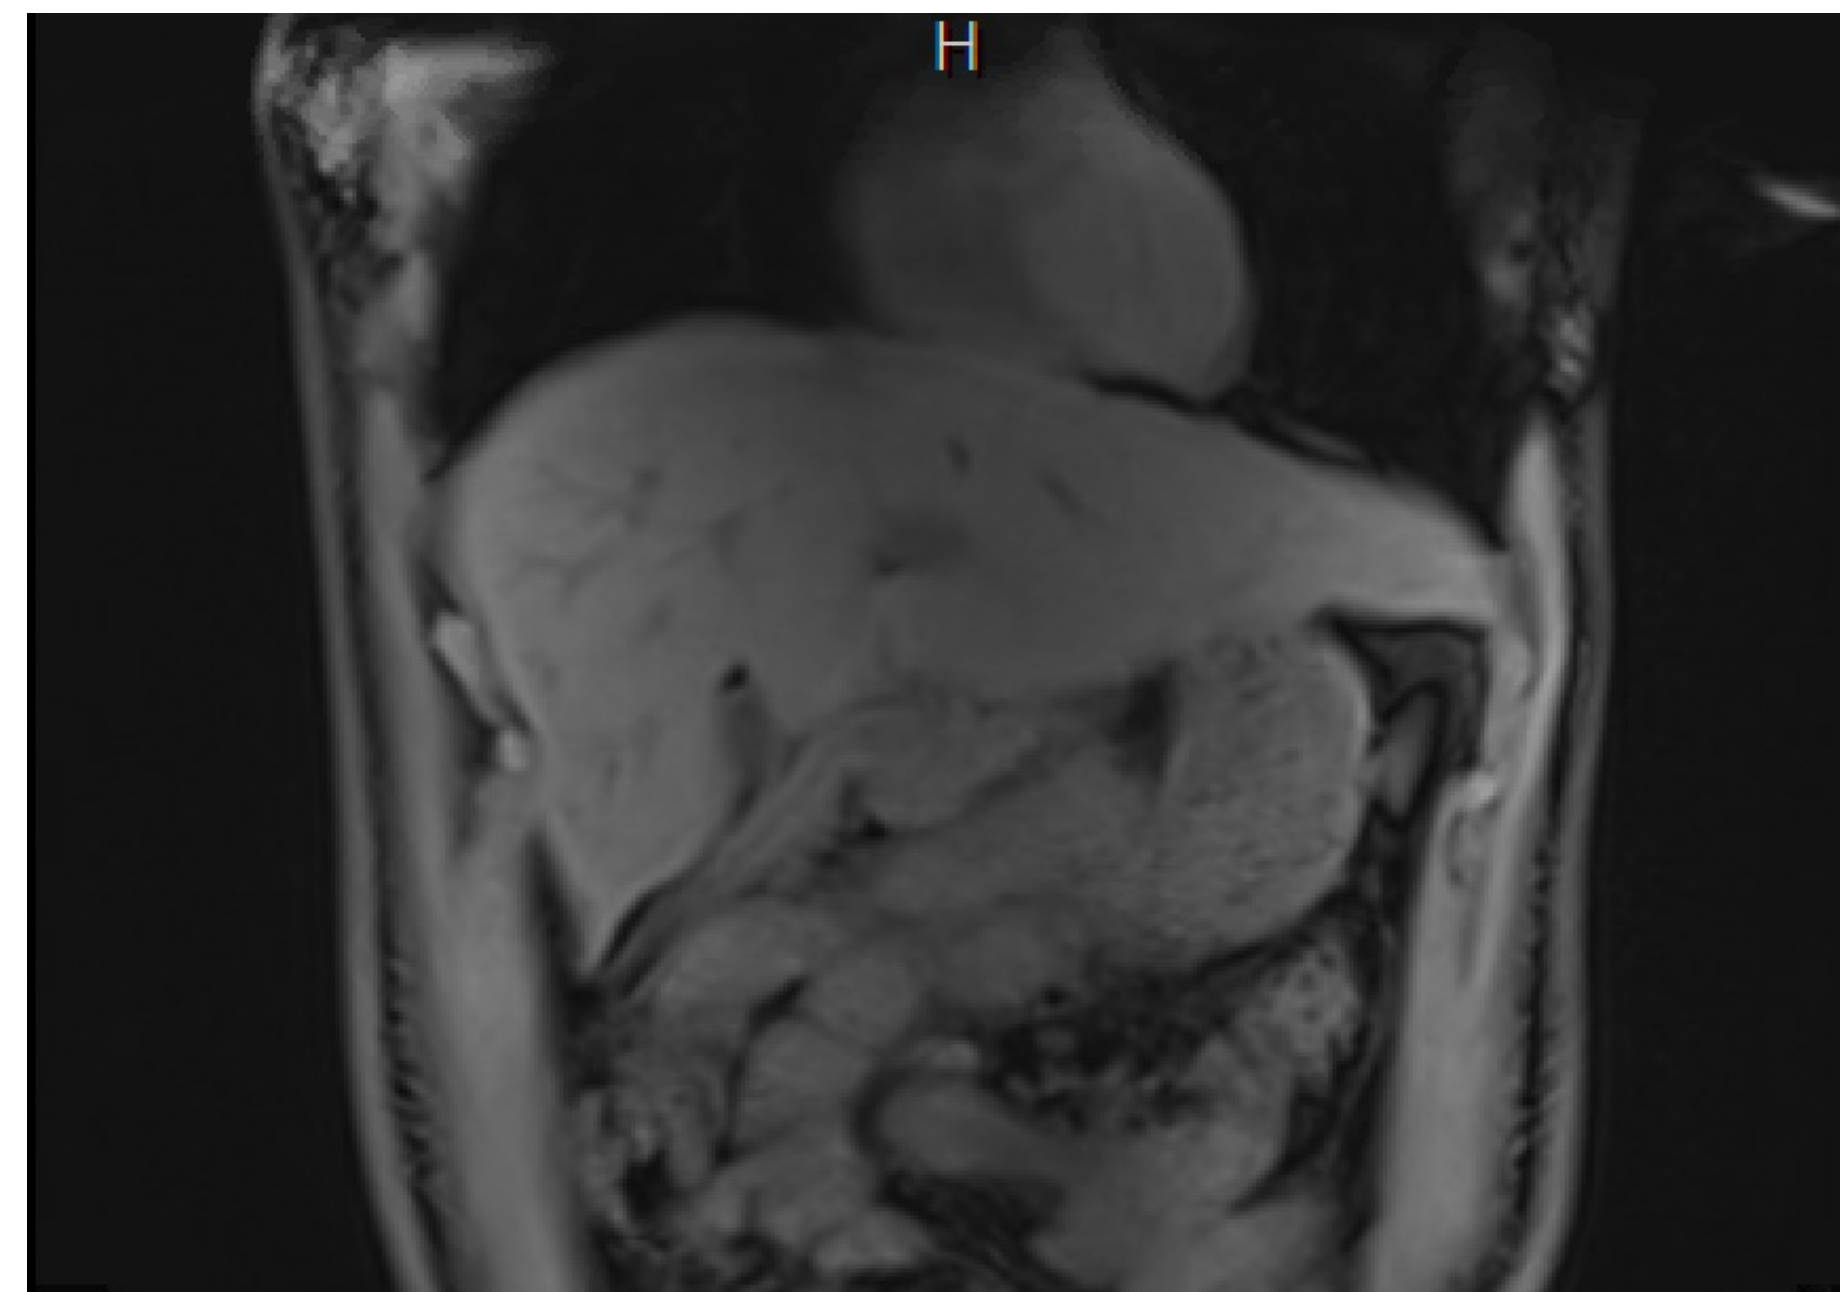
MRI showing nonspecific diffuse heterogeneous enhancement pattern of the liver parenchyma without focal lesion and moderate volume ascites.
